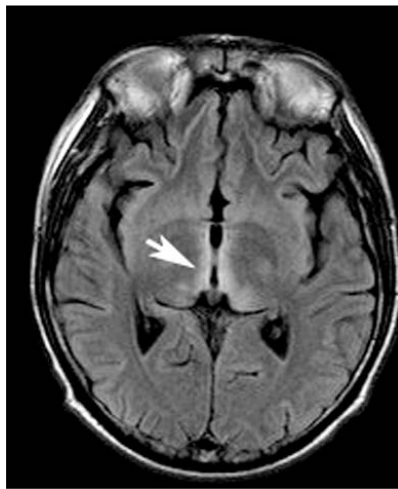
Axial FLAIR image demonstrates abnormal high signal about the walls of the third ventricle (arrow) and in the thalami.
